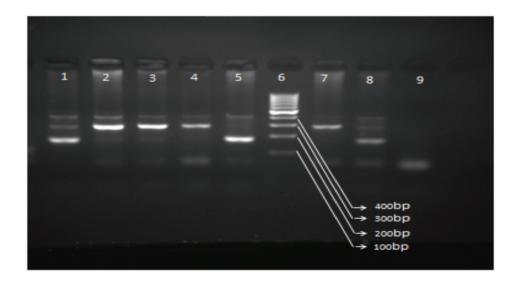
C1818T *Klotho* polymorphism. Different lanes (1-9) show various genotypes as follows: negative control (9), size marker (6), CC (2, 3, 4, 7), CT (1, 8), and TT (5). Agarose gel electrophoresis showed a few bands. The 416 bp was common for all lanes (control). CC (416bpand 291bp), TT (416bpand 179bp), and CT (416bp, 291bp, and 179bp).
